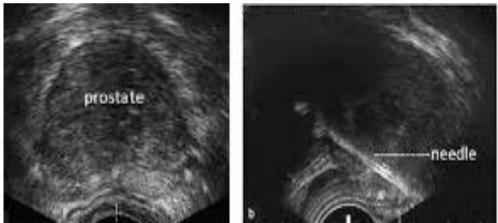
Trans rectal ultrasound scan of prostate and prostate biopsy [16]
